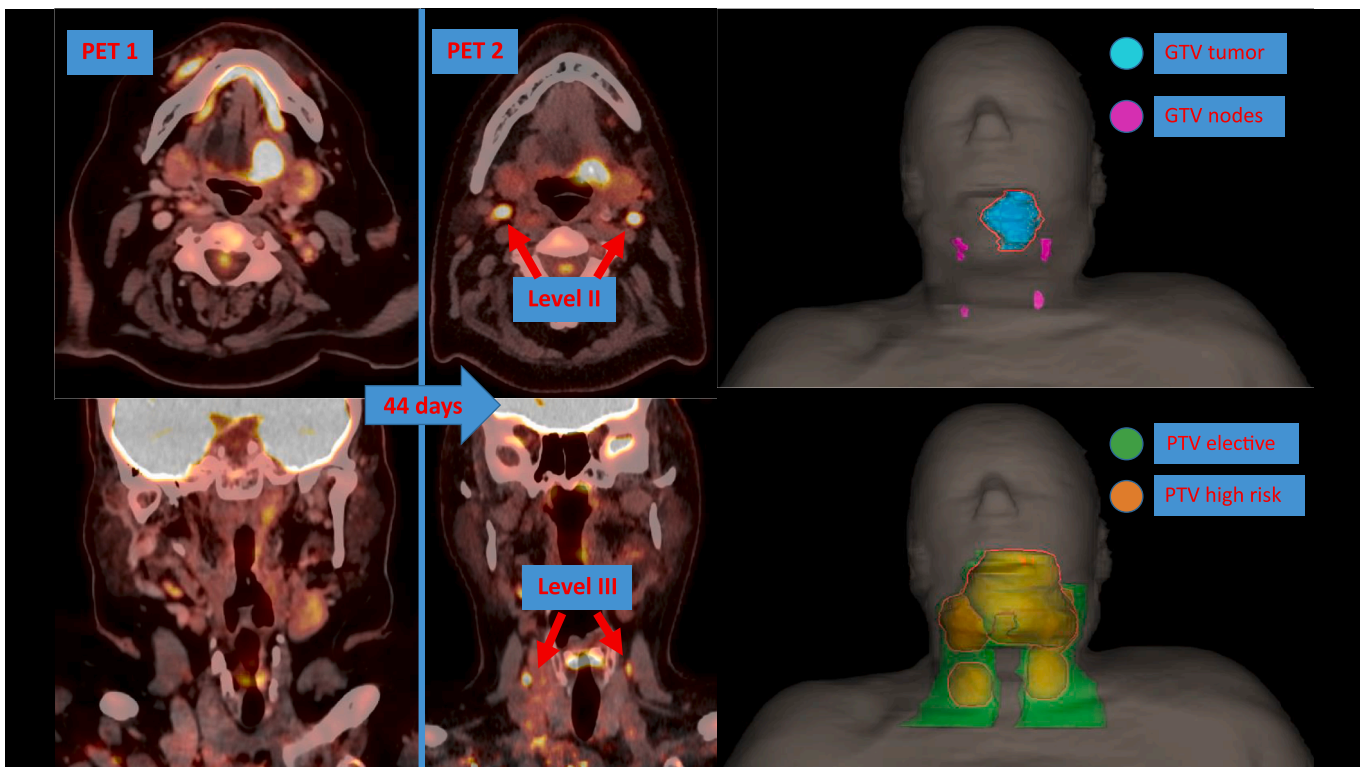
Example case who was upstaged from cN0 to cN2c Description of Fig. 2: The second look PET/CT revealed two newly involved lymph nodes in Level II bilaterally and two in level III bilaterally. Based on this information, nodal high-risk volumes were added, and the elective volume was enlarged to include levels Va + b bilaterally. Please note the positioning discrepancy between two PET/CT scans because the first was diagnostic only, whereas the second was acquired in the treatment position.
